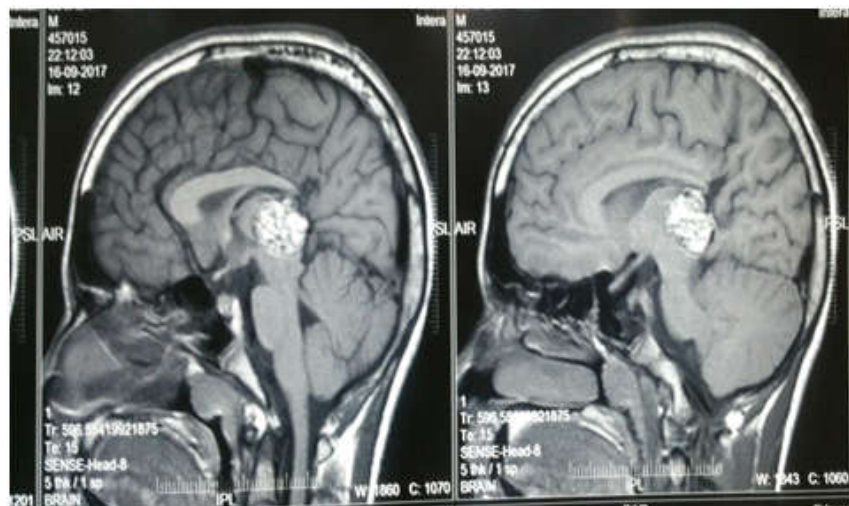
(b): MRI of Patient 2 with Pineal Cavernoma
